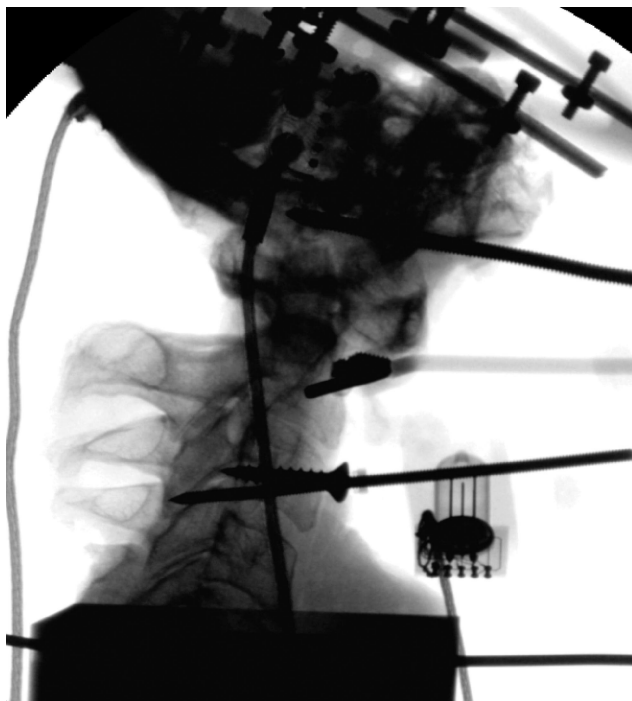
Radiograph showing surgical destabilization by transecting the transverse and alar ligaments. Note anterior subluxation of C1 on C2.
